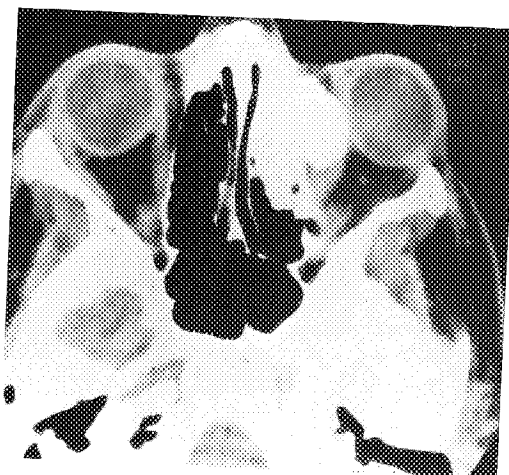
CT scan of an osteoma involving the ethmoid sinus, with extension into the medial orbital space.
